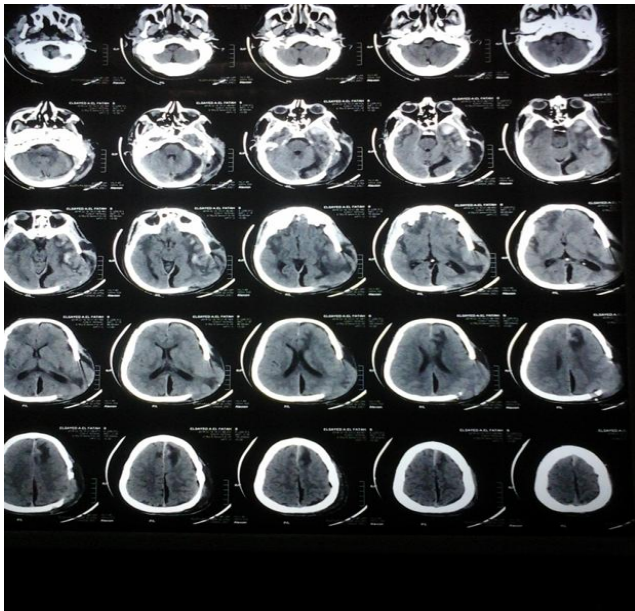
Post-operative CT brain of Case 2
